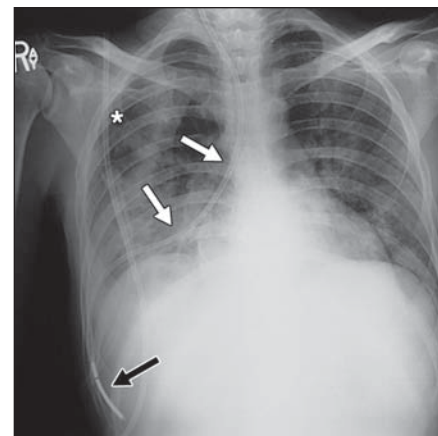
30-year-old man with malpositioned feeding tube. Anteroposterior chest radiograph shows that feeding tube has entered right main bronchus, traversed right lower lobe bronchus (*white arrows*), and has its tip overlying right upper quadrant of abdomen (*black arrow*), raising concern for possible perforation of right hemidiaphragm. Note associated right pneumothorax (*asterisk*).
